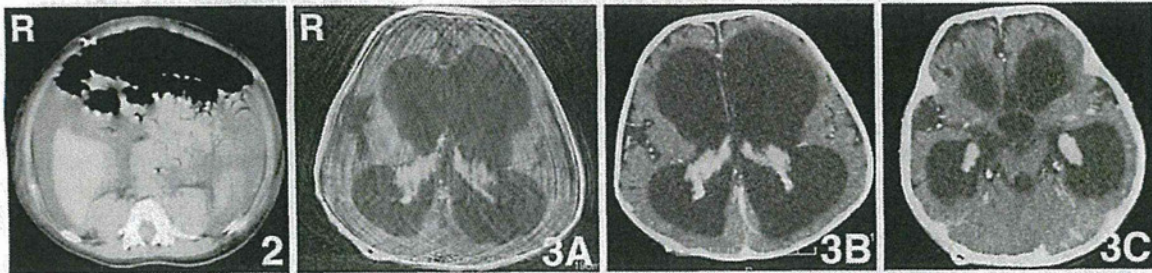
Abdominal computed tomography scan on the day after the first operation revealing massive free fluid in the peritoneum. Fig. 3 T₁-weighted magnetic resonance image (A) and computed tomography scans (B, C) with contrast medium showing no mass lesion, but the markedly enhanced bilateral choroid plexuses.
